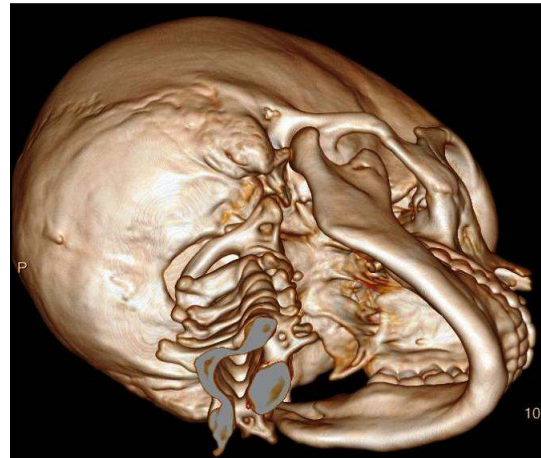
4 months follow-up CT scan showing satisfactory healing of the zygomatic arch fracture and no ankylosis between the coronoid process and the zygomatic arch
